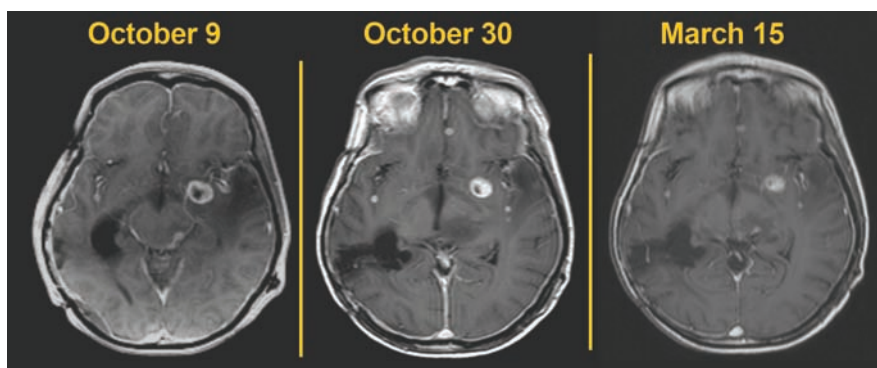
Post contrast T1-weighted axial images of the brain showing stable appearance of the metastases over 5 months of therapy. Despite the difference in technique between these imaging studies a minimal reduction in size of the tumor deposits can be noticed with additional therapy.
